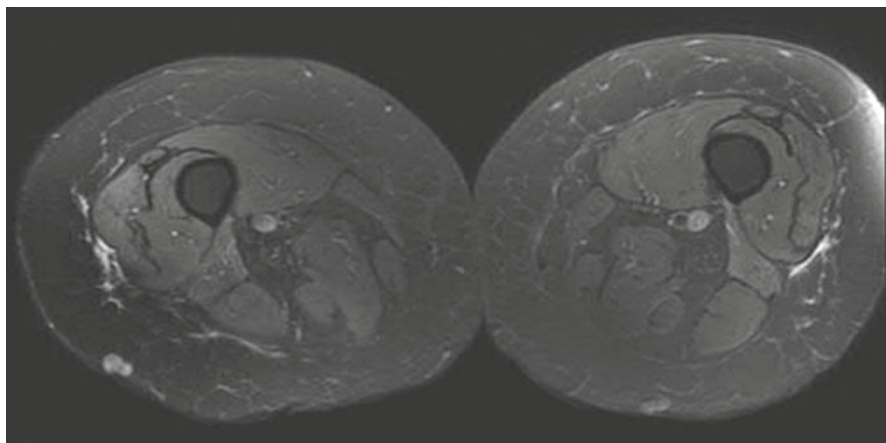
Magnetic resonance imaging of the bilateral thighs without intravenous gadolinium in a patient with anti-synthetase syndrome revealing increased T2 signal within the anterior aspect of the short head of the biceps femoris muscles, bilaterally
